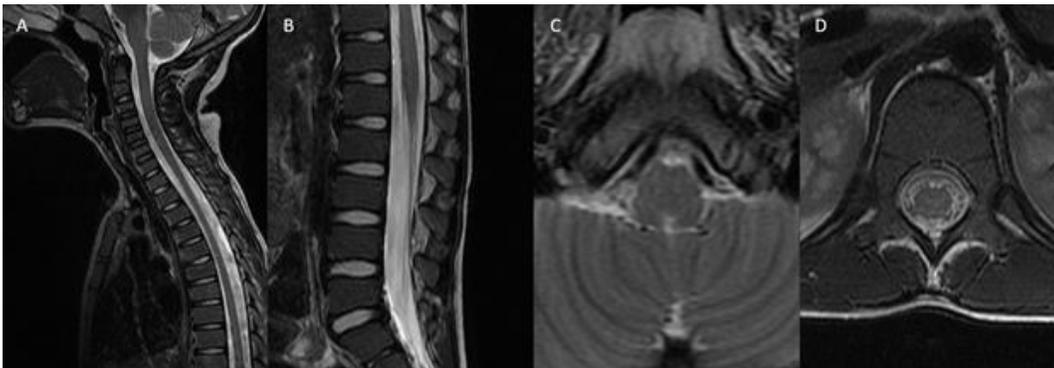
Full spine MR imaging on day seven of hospitalization. Sagittal T2-weighted image at the level of the cervical spine shows resolution of the subtle abnormal hyperintense signal previously noted at the cervicomedullary junction that continued in the medulla and the dorsal pons (A). Sagittal T2-weighted image at the level of conus medullaris shows resolution of the previously noted central hyperintense signal abnormality (B). Axial T2-weighted image at the level of medulla oblongata shows resolution of the subtle hyperintense signal abnormality previously noted (C). Axial T2-weighted image at the level of the conus medullaris shows resolution of central hyperintense signal abnormality previously noted (D).
